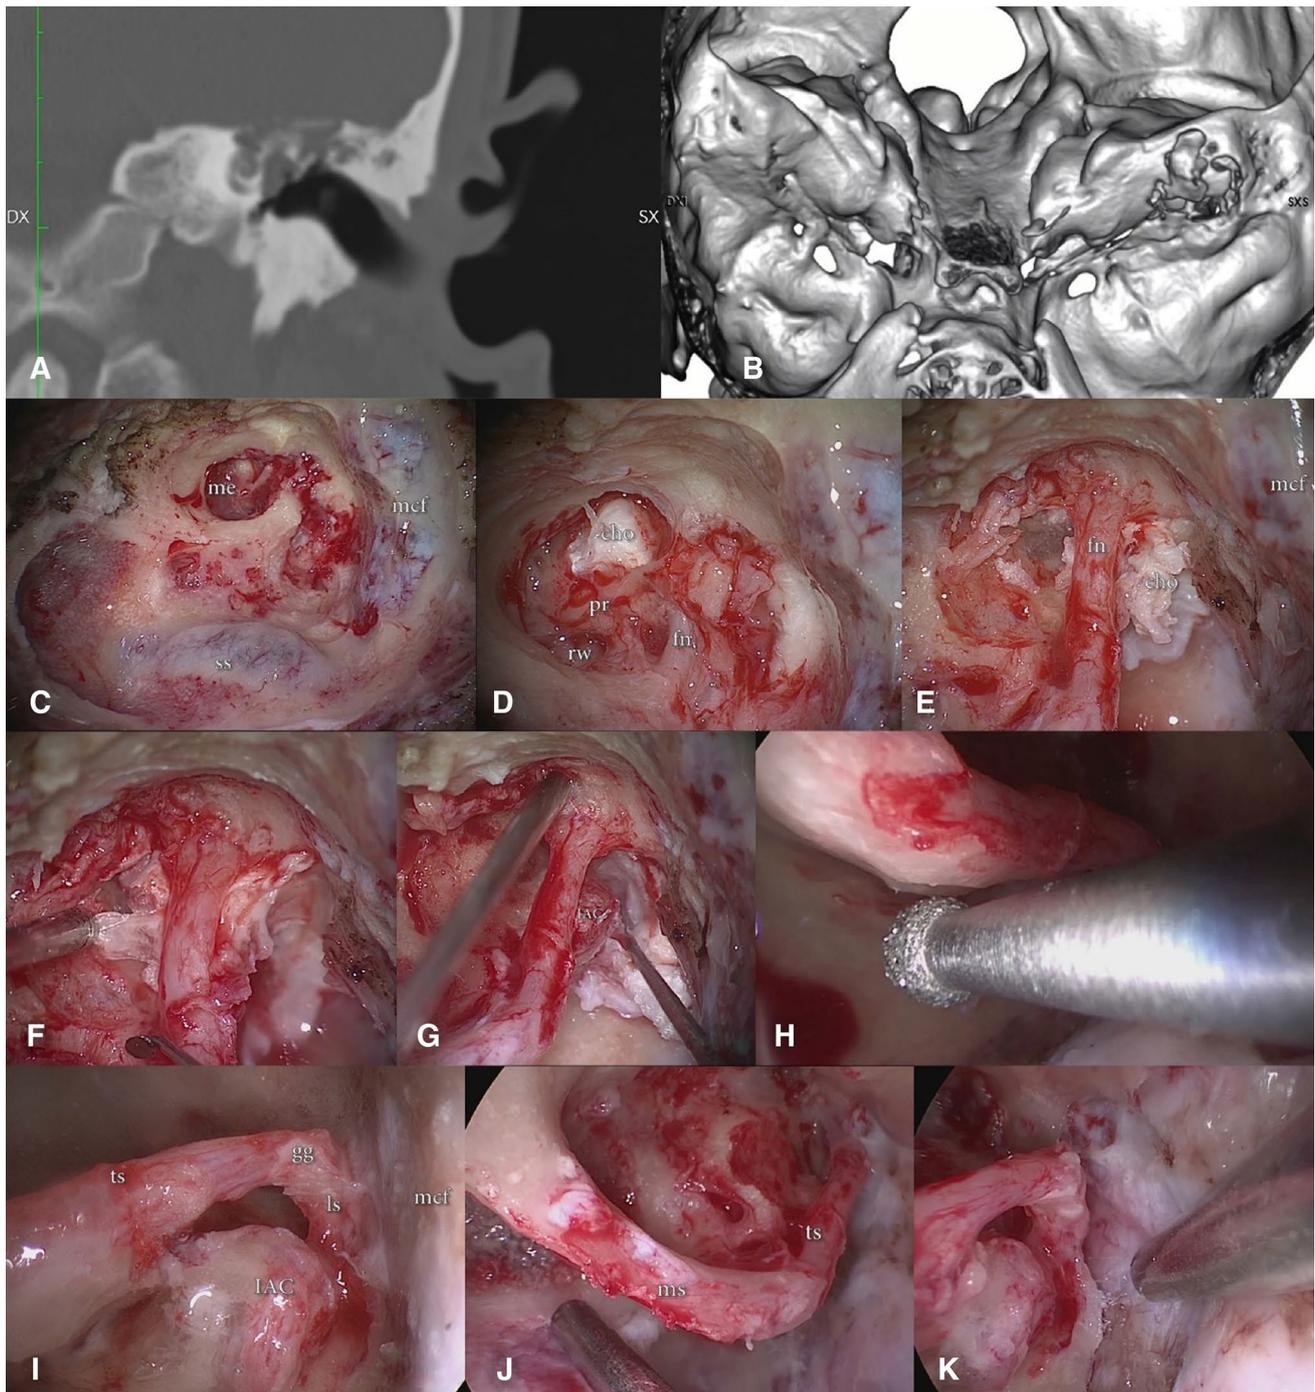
Endoscopic-assisted translabyrinthine approach. Left ear. a CT scan; b 3D reconstruction (right panel) showing the extension of the pathology to the medial aspect of the petrous bone, the geniculate ganglion, the middle ear, and the labyrinthine and tympanic portions of the facial nerve. c Canal-wall-down mastoidectomy; *me* middle ear, *ss* sigmoid sinus, *mcf* middle cranial fossa; d the cholesteatoma occupying the middle ear, *cho* cholesteatoma, *fn* facial nerve, *rw*
